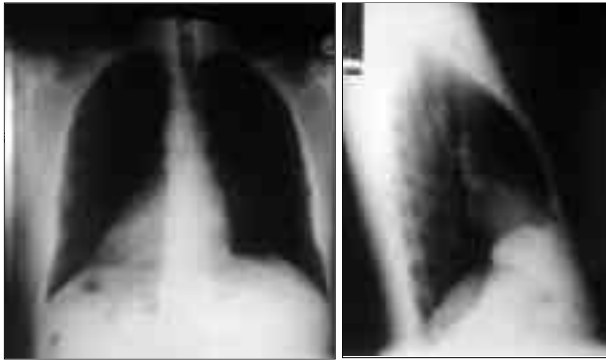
Postero-anterior and lateral views of Chest X-ray showing dextrocardia
